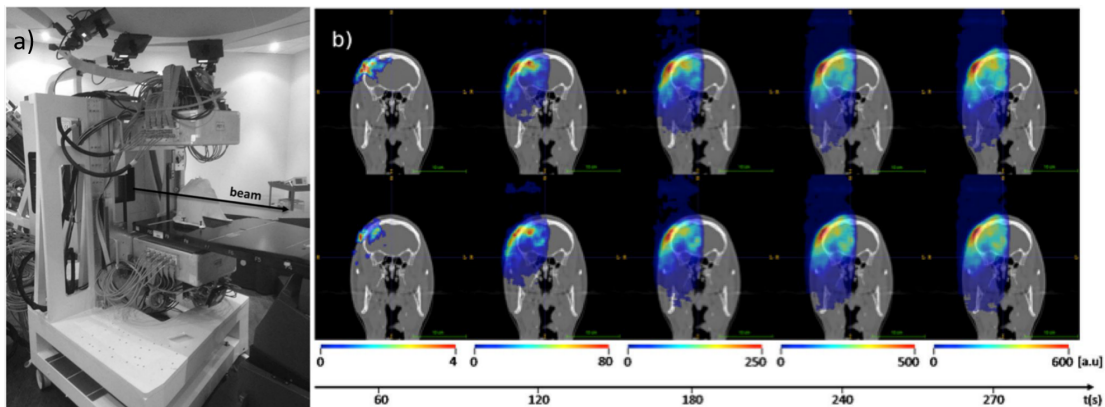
a) The prototype of the INSIDE PET detector developed at CNAO, Pavia. b) Reconstructed activities measured with the detector superimposed onto patient CT for two subsequent proton treatment fractions (top and bottom). Presented PET images were reconstructed every 60 seconds up to the final total activity, including 30 seconds post-irradiation acquisition. Figure adapted from [15]
